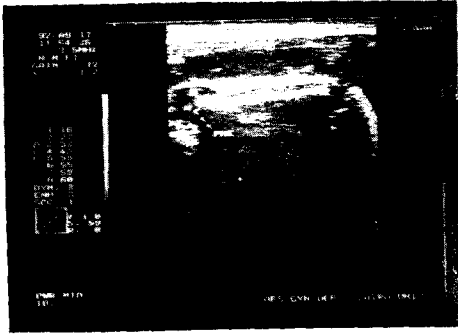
Longitudinal real-time sonogram of the fetal humerus clearly demonstrates the ecogenic PHE.
